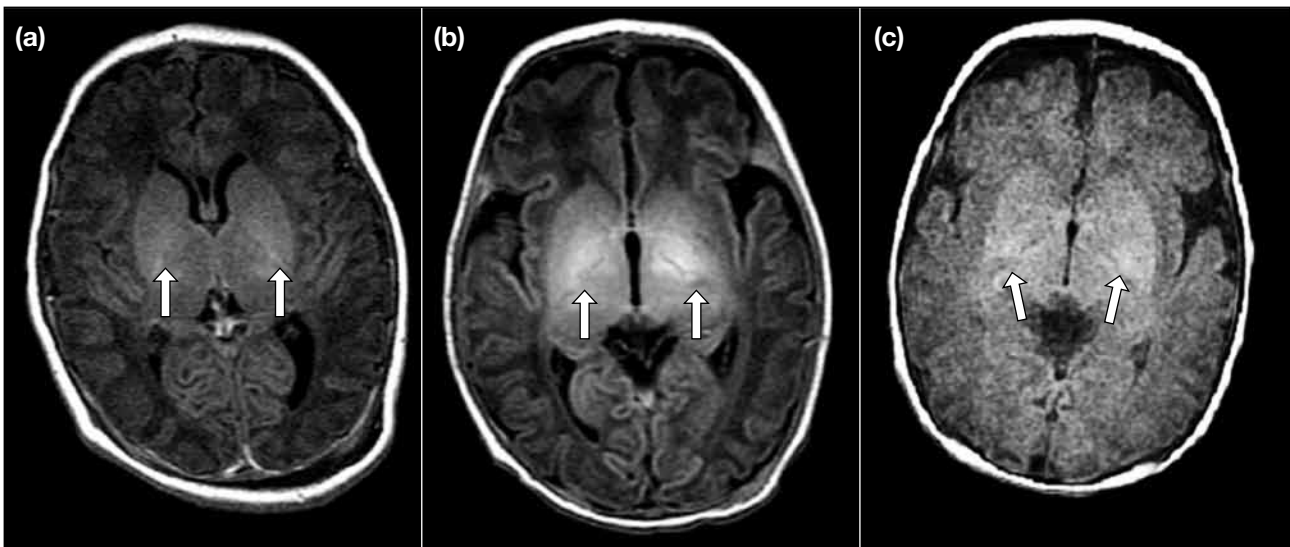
Magnetic resonance imaging of the posterior limb of the internal capsule (arrows) showing (a) normal signal (preserved symmetrical T1 hyperintensity), (b) equivocal signal (preserved but asymmetrical T1 hyperintensity), and (c) abnormal signal (loss of T1 hyperintensity).
